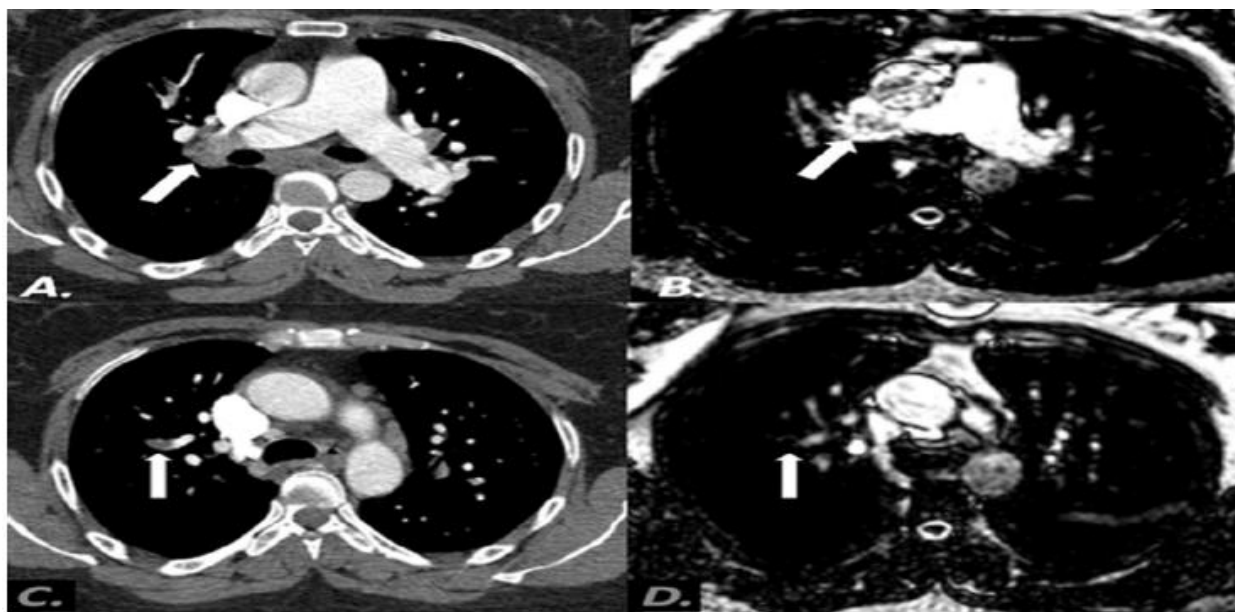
a Female patient 50 years old presented with dyspnea and chest pain with high probability of PE according to Well’s score. (A)Axial CT image demonstrates pulmonary embolism involving the right (arrow) and left (arrow head) lower lobar divisions. (B) Axial MR-PA-WB taken 24 h later reveals the same result with the pulmonary embolism appearing as hypointense material.
